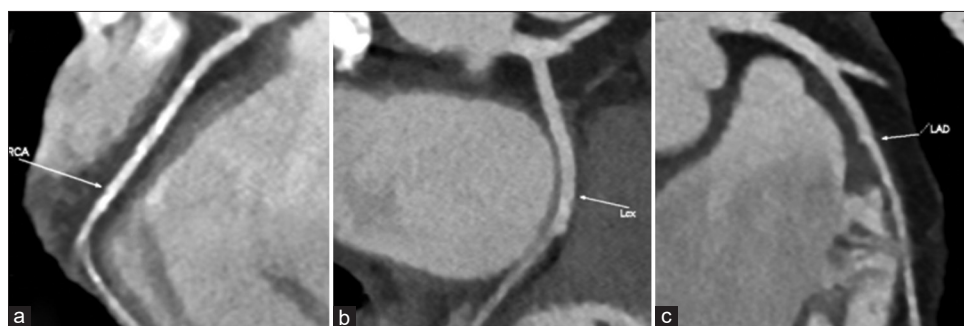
CT angiography shows unobstructed coronary arteries; (a) right coronary artery; (b) left circumflex coronary artery; (c) left anterior descending coronary artery
